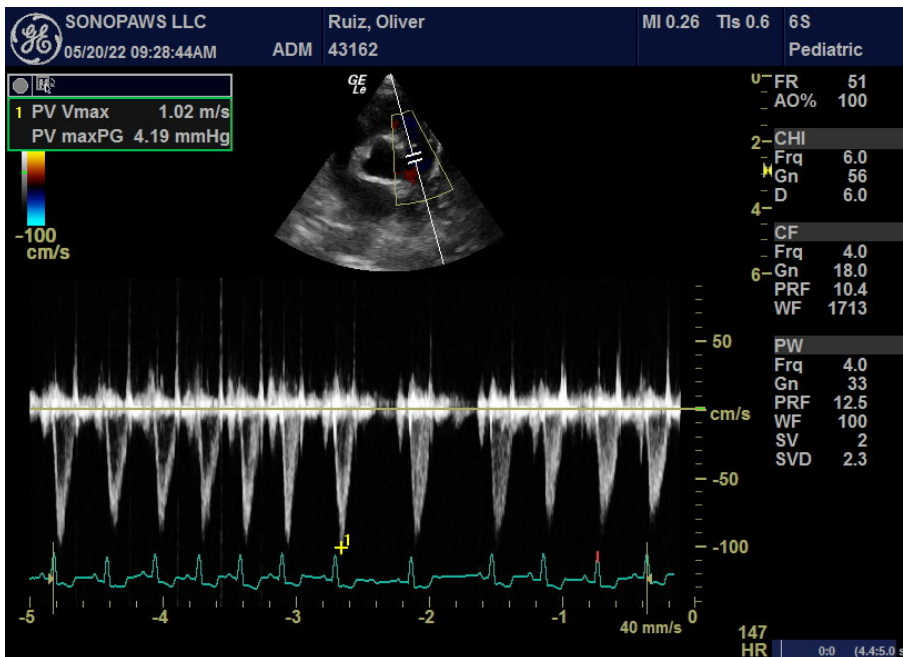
Right parasternal short axis view of the pulmonary artery. Normal peak velocity of 1 m/sec with laminar flow on PW.
